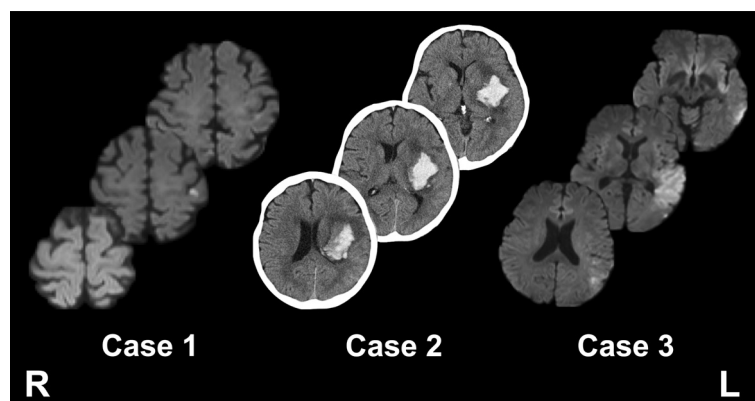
Diffusion-weighted magnetic resonance images (Cases 1 and 3) and computed tomography images (Case 2) for the three patients included in this report. L: left; R: right.
